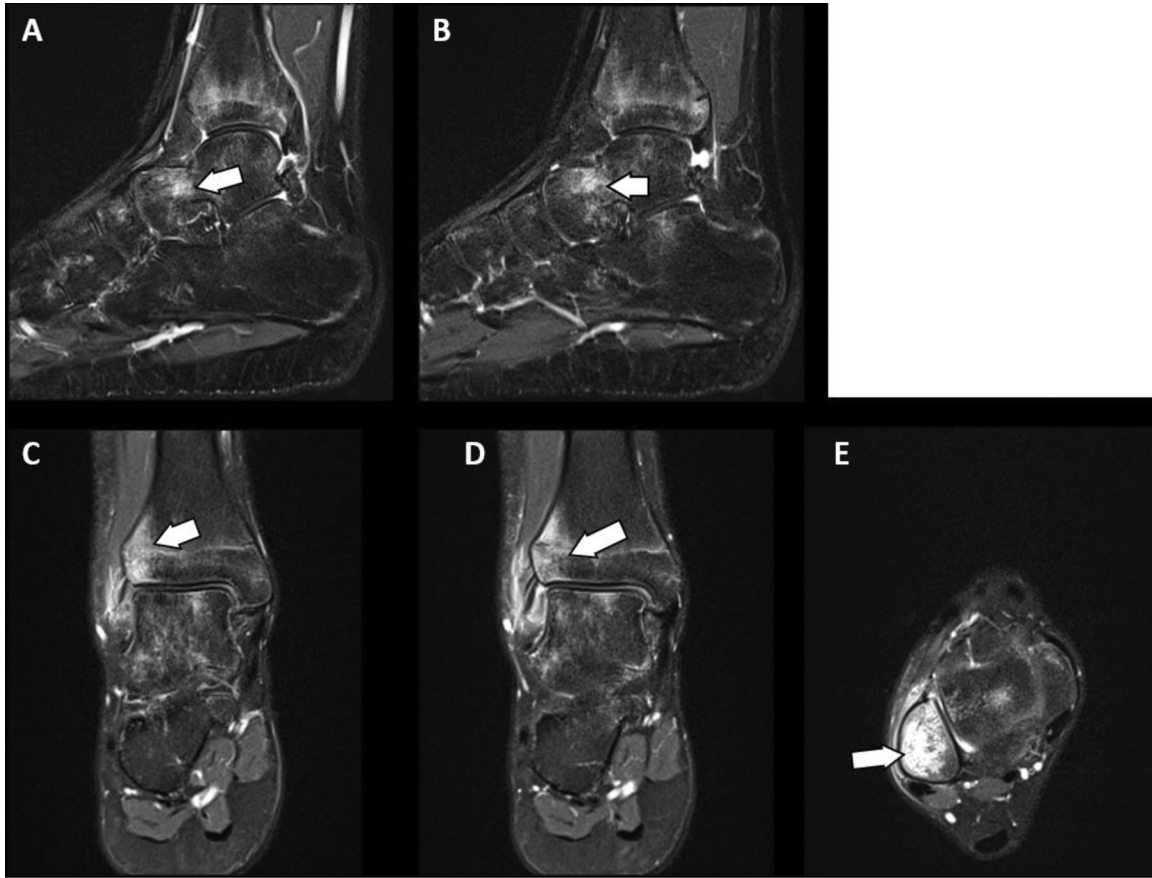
A, B: Sagittal STIR ankle (right) MRI. C, D – Coronal proton density (PD) fat saturation ankle (right) MRI. E – Axial PD fat saturation ankle (right) MRI. Osteitis with bone marrow oedema in the distal tibia, talus and fibula with adjacent soft tissue inflammation. MRI, magnetic resonance imaging; STIR, short time inversion recovery.
